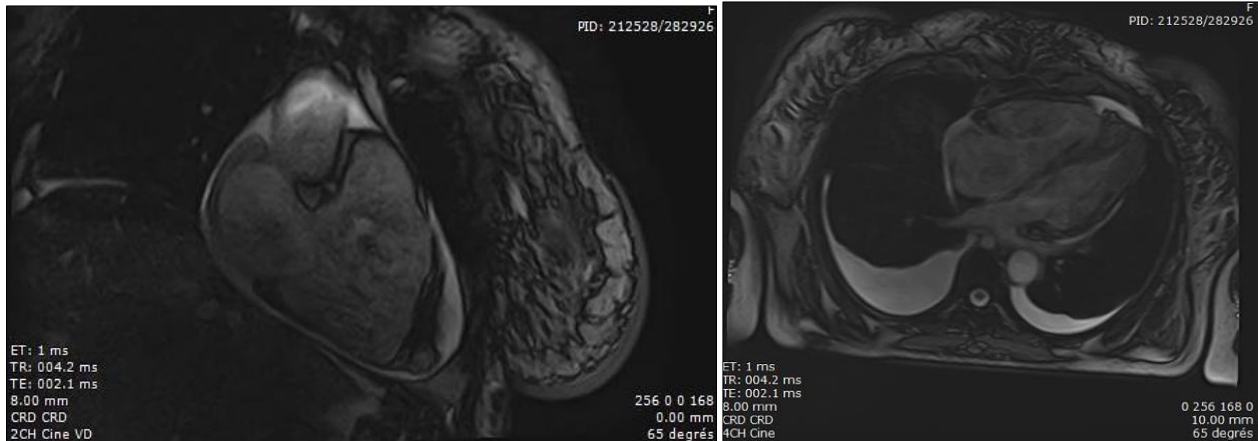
Cine-MRI (SSFP: Steady-State Free Precession), four-chamber view and two-chamber right ventricle view: showing dilation of the right chambers, apical hypertrophy of the left ventricle, and pericardial and pleural effusion
